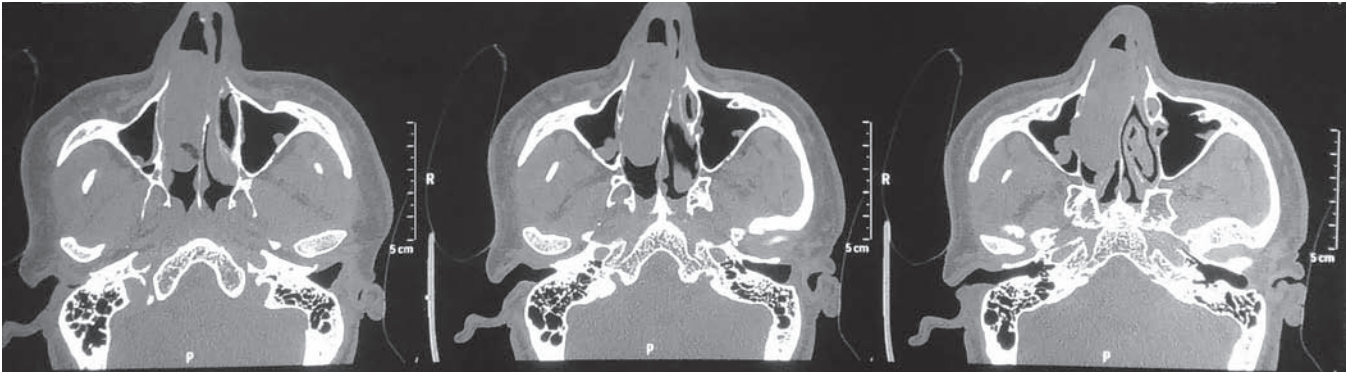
Computed tomography scan (axial cuts) show polypoidal mass in the right nasal cavity
